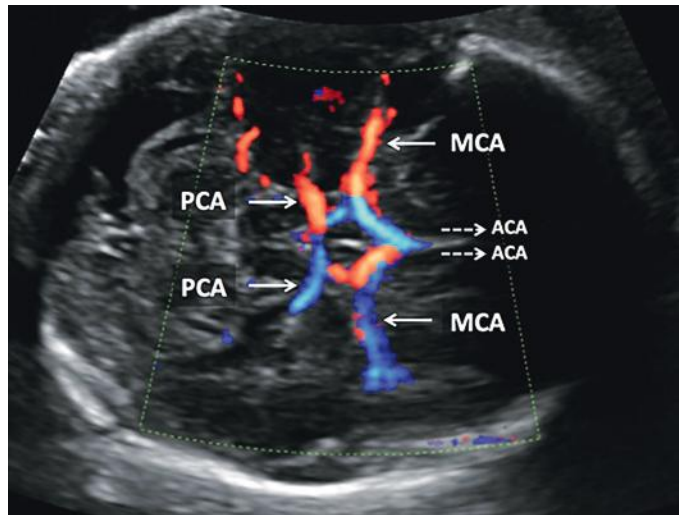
Circle of Willis shown on color Doppler imaging. ACA, anterior cerebral artery; MCA, middle cerebral artery; PCA, posterior cerebral artery. (From *Ultrasound in Obstetrics & Gynecology: A Practical Approach*. Available at www.openultrasound.com. Used with permission.)
